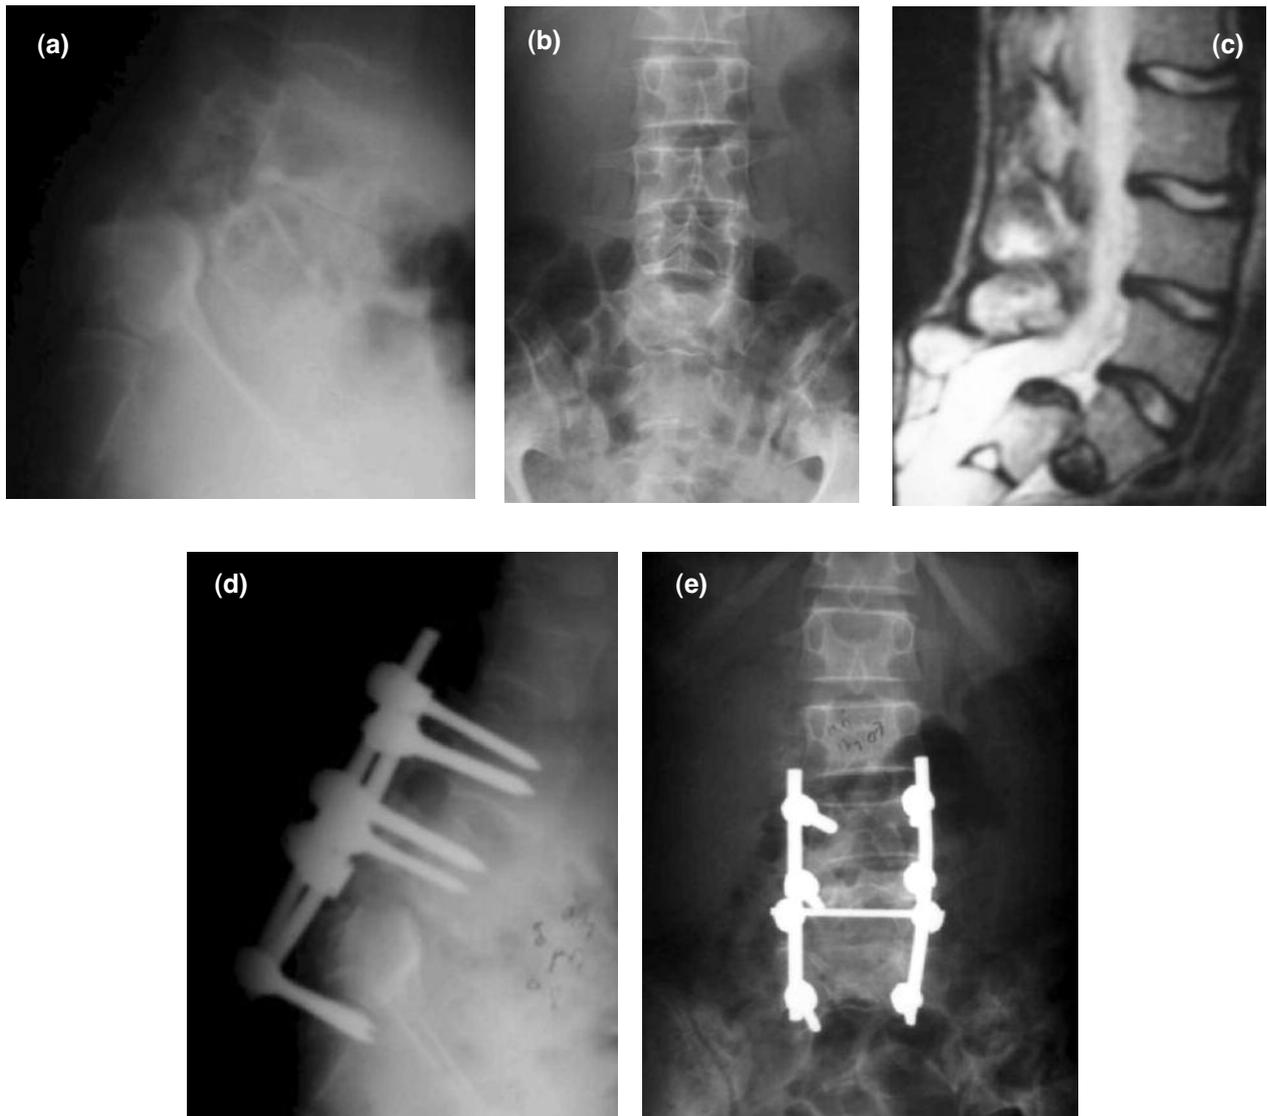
Preoperative lateral (a), posteroanterior (b) graphics and axial MRI section (c), and postoperative lateral (d) and posteroanterior (e) graphics of the second patient.
